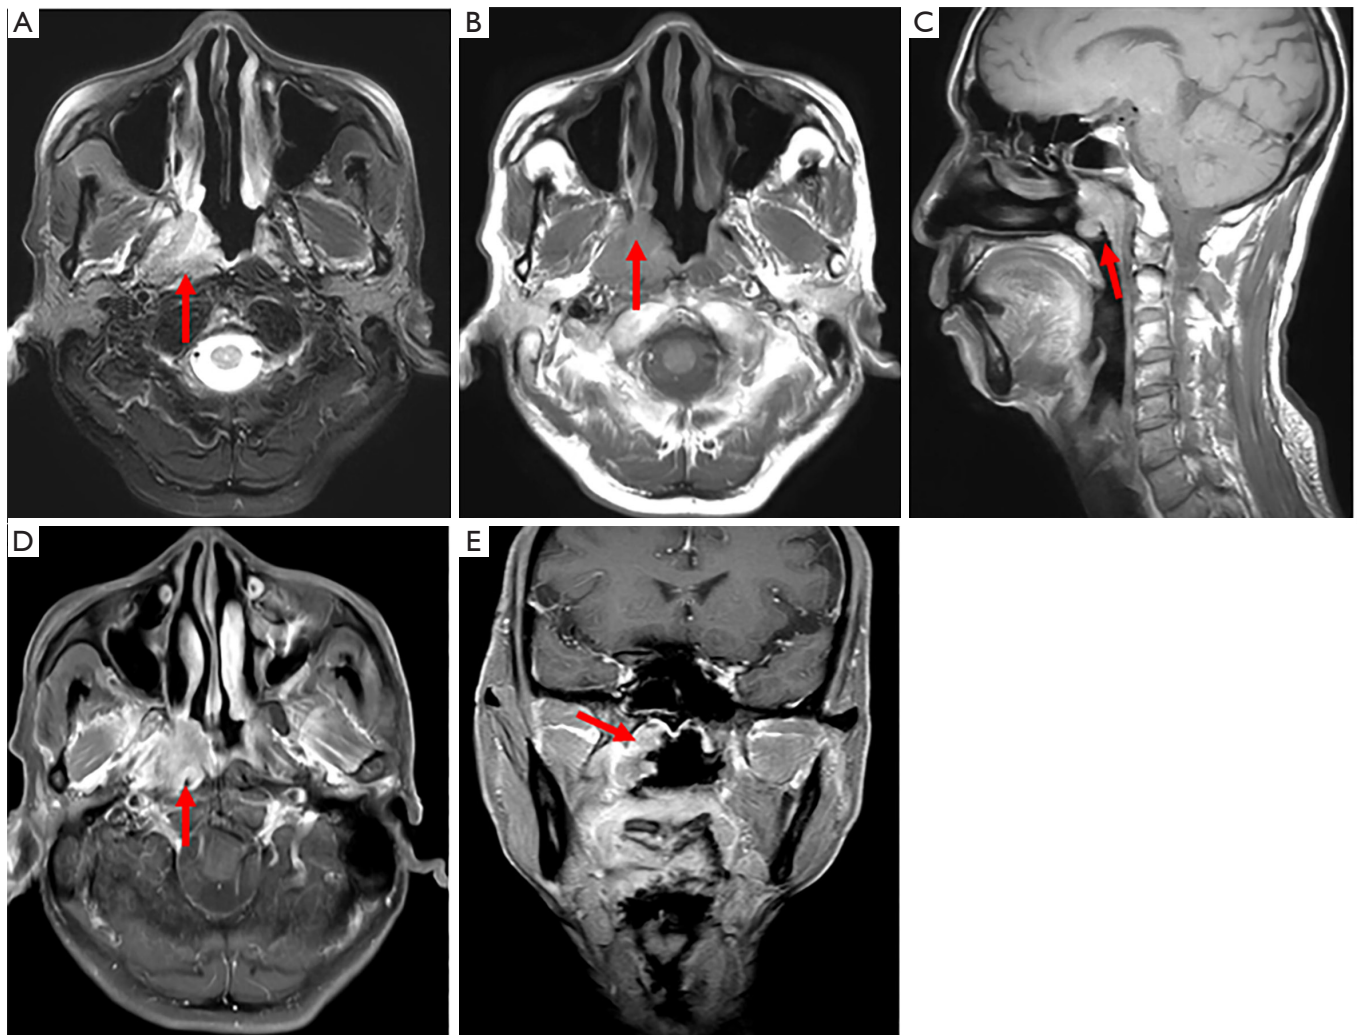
MRI images of nasopharyngeal cancer. Nasopharyngeal carcinoma grade III ($T_3N_1M_0$): the right pharyngeal recess has disappeared, soft tissue masses are visible in the right pharyngeal wall and the posterior parietal wall, the right internal and external pterygoid muscles and the right posterior nostril are invaded, and the skull base bones are damaged. (A) Transaxial T2 with lipid suppression, (B) transaxial T1WI, (C) sagittal T1WI, (D) transaxial contrast-enhanced scan, and (E) coronal-enhanced scans.
